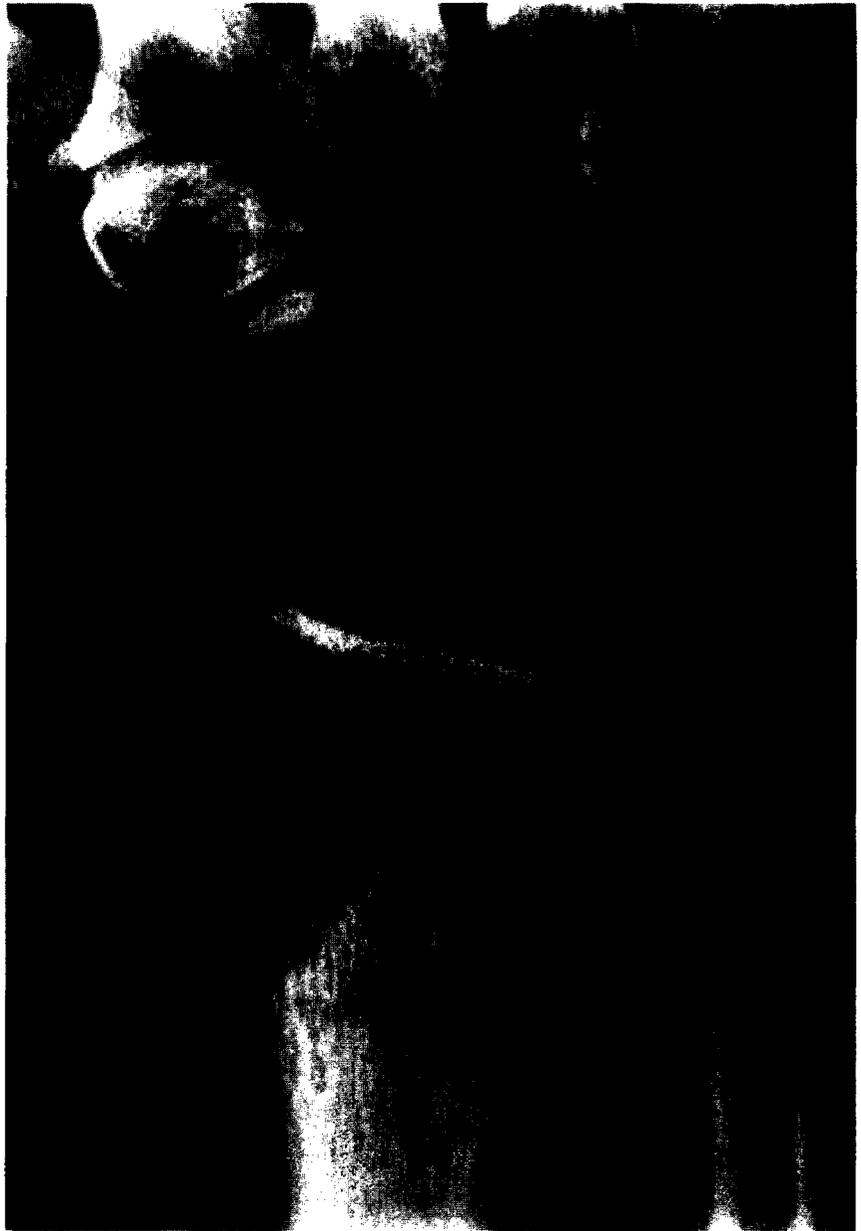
Osteoblastoma of the distal radius has a nonspecific radiographic appearance. Note the poor margination.
